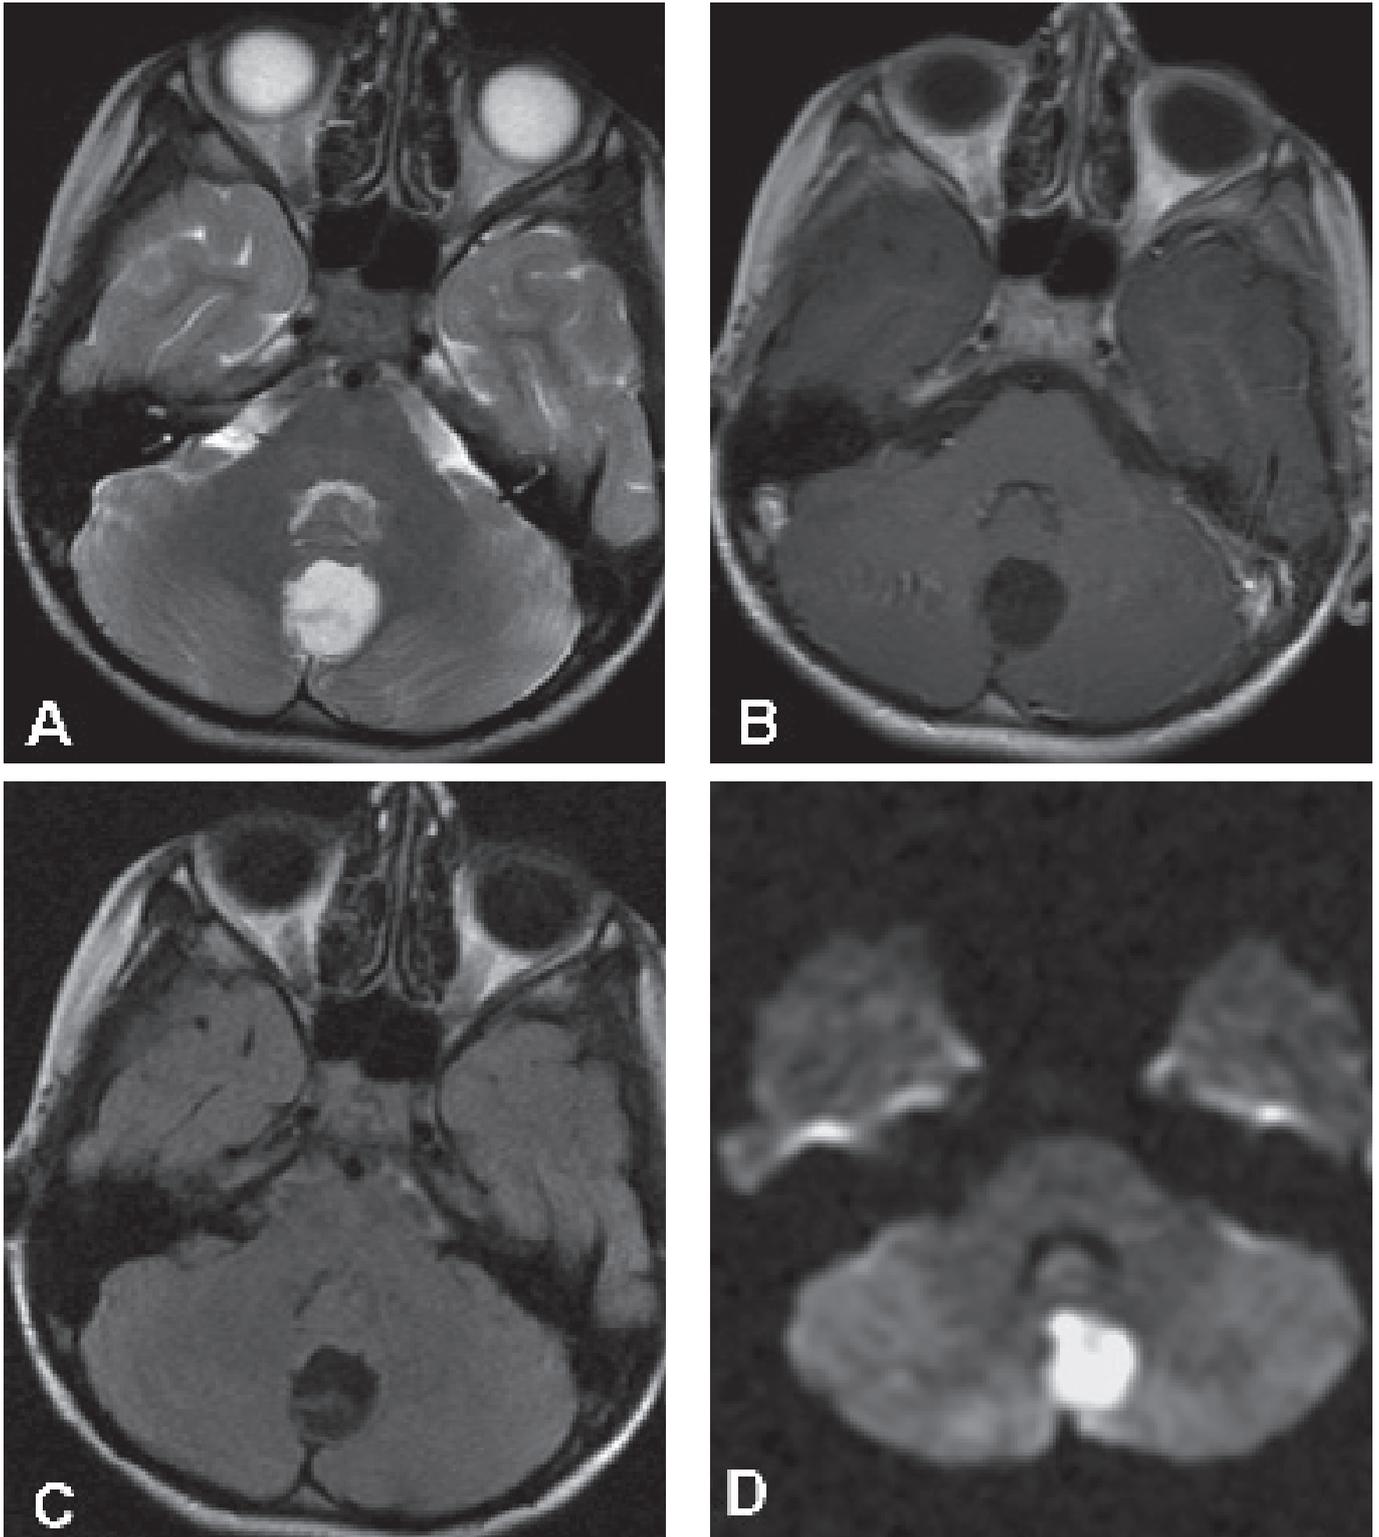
An 8-year-old boy with a vermian epidermoid cyst. Axial T2- (A) and postcontrast T1- (B) weighted images show a well-margined cystic lesion in the vermis that does not show contrast enhancement on the postcontrast image (B). On the FLAIR image (C), the lesion is isointense to CSF. DWI (D) shows that the cyst has bright signal intensity, which causes a clear contrast with the dark signal of the CSF.
